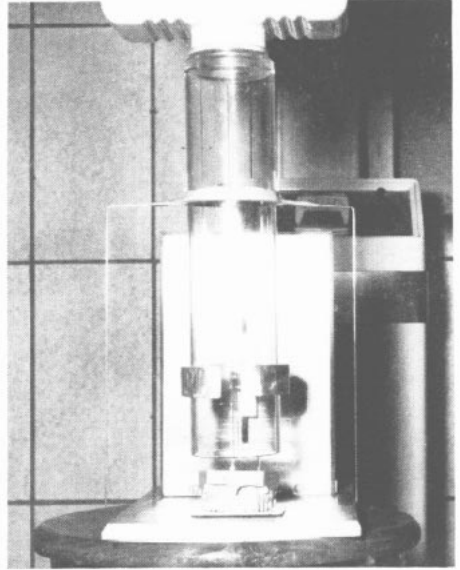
Photograph of aluminum positioner used in x-raying models.
